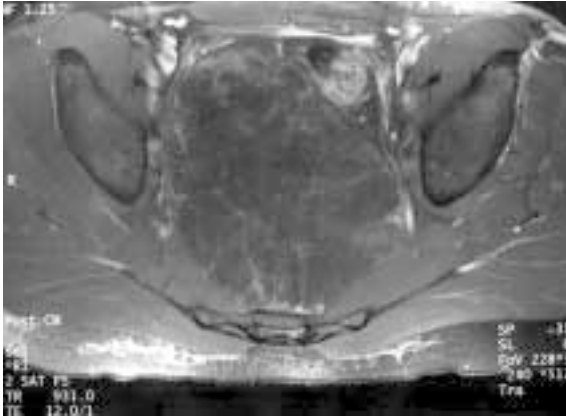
19-year-old Caucasian man who presented with perineal pain and constipation for four months. Enhanced axial fat suppressed T1-weighted MR image taken through this large pelvic tumour shows only patchy enhancement. Note the numerous septations contrasted against the dark greyish tone of the tumour tissue. The piriformis muscles and the 4th sacral segment are intact. In this case, the chordoma arose from the coccyx. There is enhancement of the more superficial layer of the right gluteus maximus muscle.
